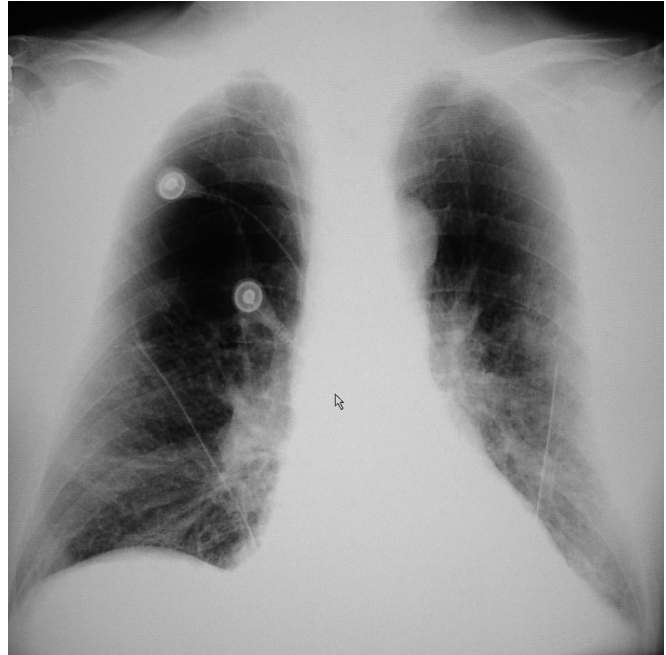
Chest x-ray on the first day following surgery.
